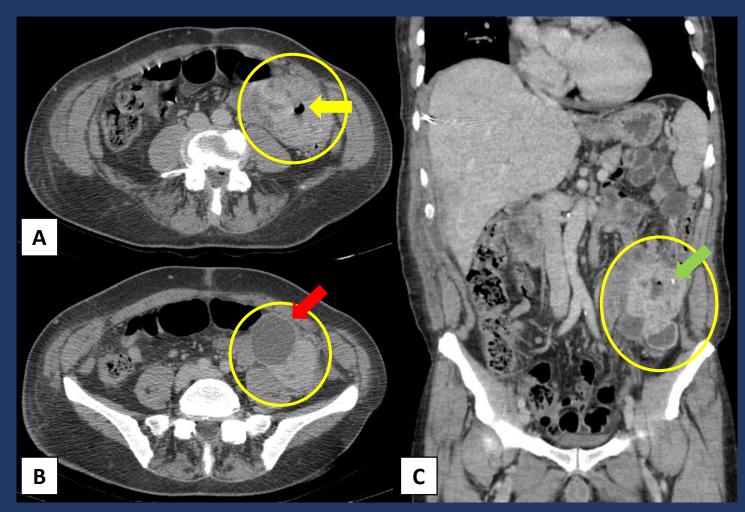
Axial (A, B) CT shows an exophytic mass (circle) in the dependence of a jejunal loop, with heterogenous contrast uptake, central gas (yellow arrow) and adjacent cystic components (red arrow). In the coronal (C) CT scan there is a small calcification inside the lesion (green arrow). These aspects are suggestive of GIST, which was confirmed after surgical resection.
